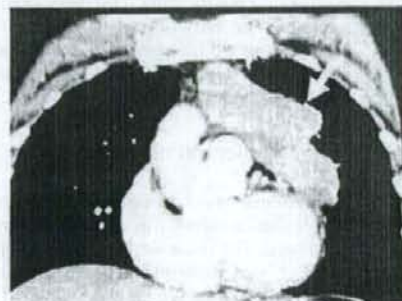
A 58-year-old woman with Type B1 in Masaoka stage IVa. An irregular-shaped tumor with an uneven margin was found projecting to the left side of the anterior mediastinum. CT also indicated tumor dissemination, which suggested malignancy that exceeded that of a high-risk thymoma, but ^{18}F -FDG accumulation in the tumor was similar to that in the mediastinum, with a T/M ratio of 1.70. This was thought to be a low-risk thymoma.
